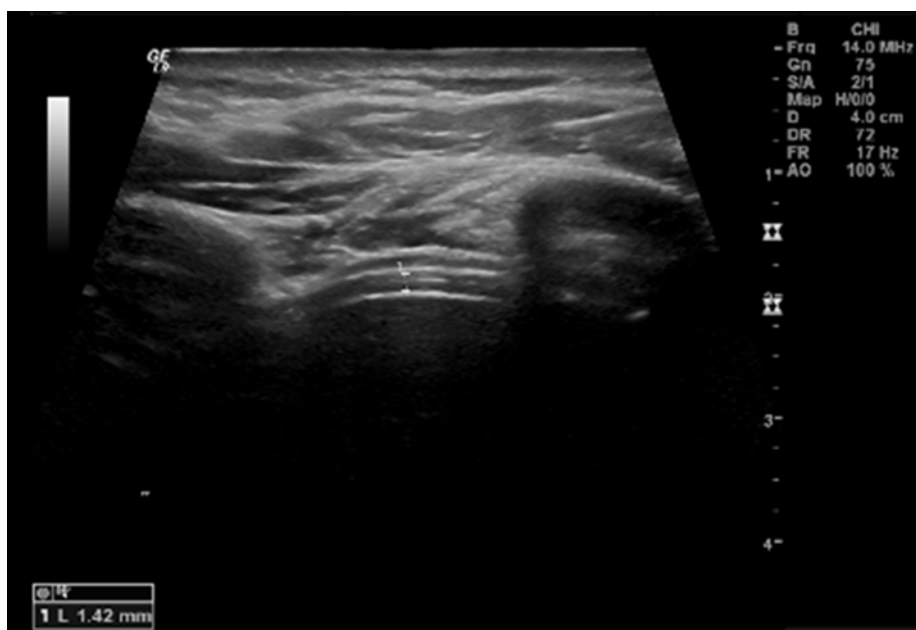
Measurement of diaphragm thickness using ultrasound
